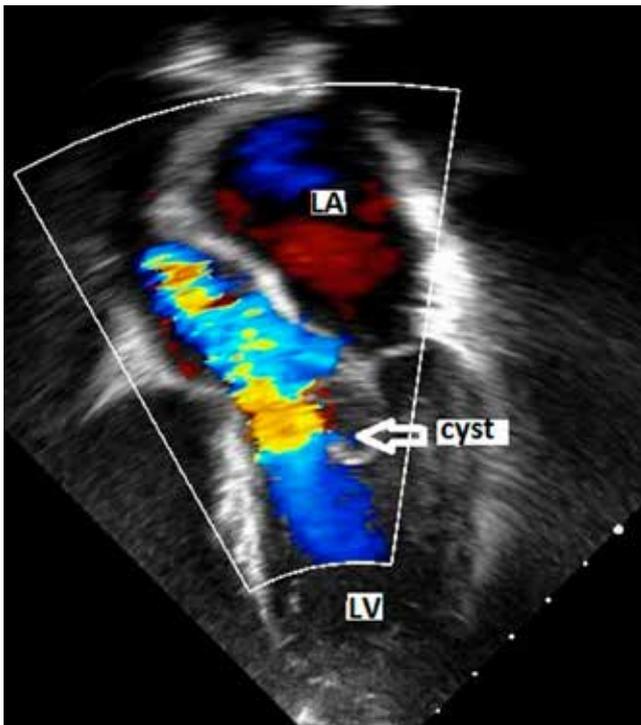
Transthoracic echocardiogram – apical 5 chamber view. Left ventricle outflow tract obstruction due to the blood cyst (white arrow) attached to the anterior mitral leaflet
